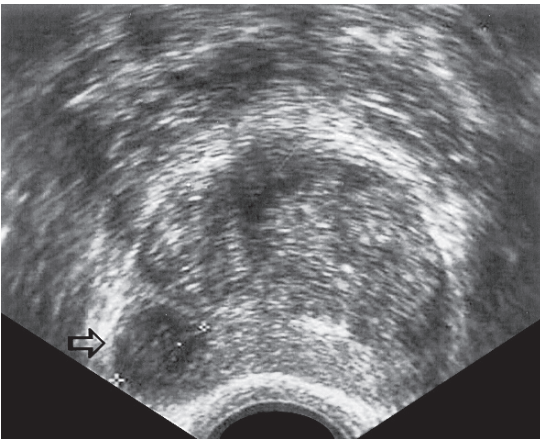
Transverse transrectal ultrasound image depicting focal nodular (open arrow) pattern of PC
